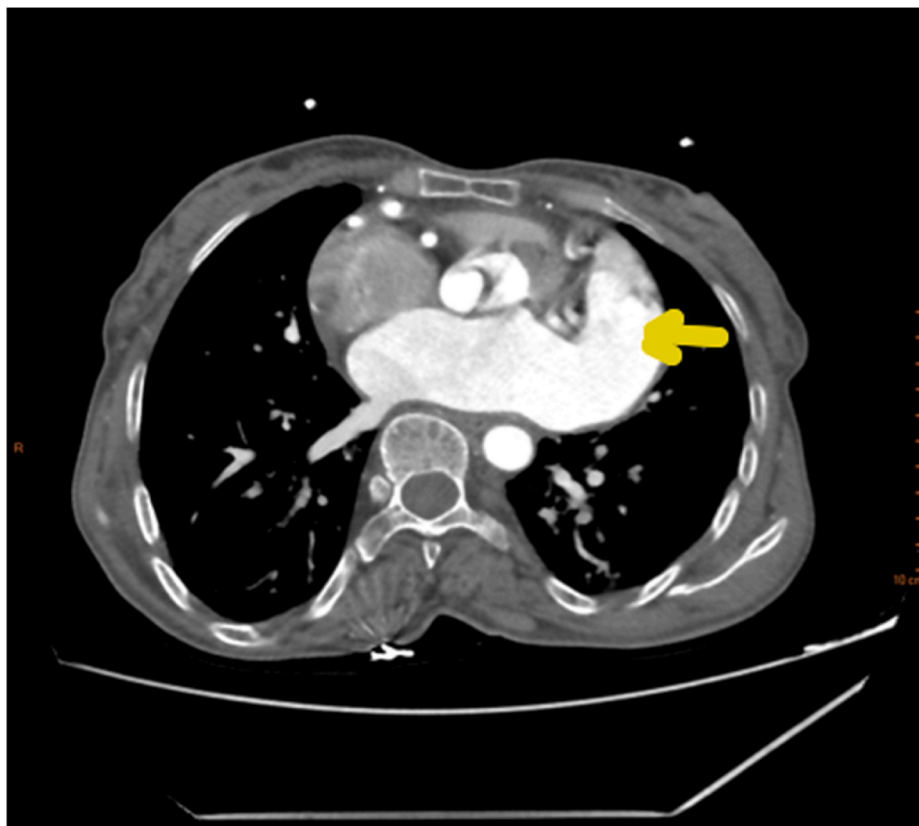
Axial chest CT with injection of the contrast showed a LAAA.
